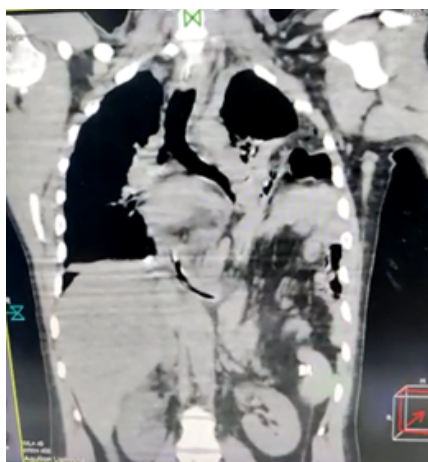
(CT thorax coronal view showing herniated abdominal viscera)
